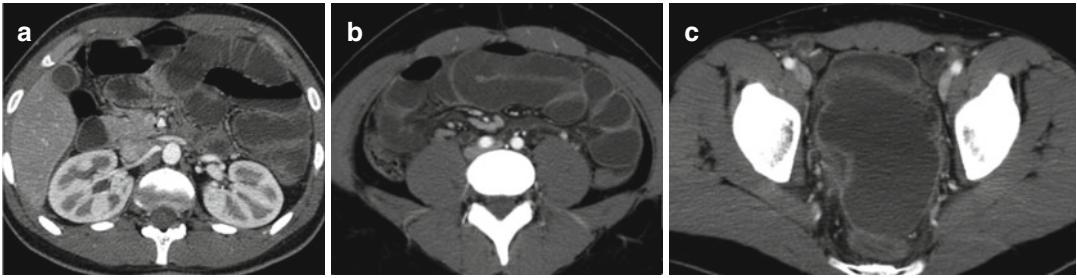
(a–c) CT axial, same patient: evidence of small-bowel obstruction and peritonitis
